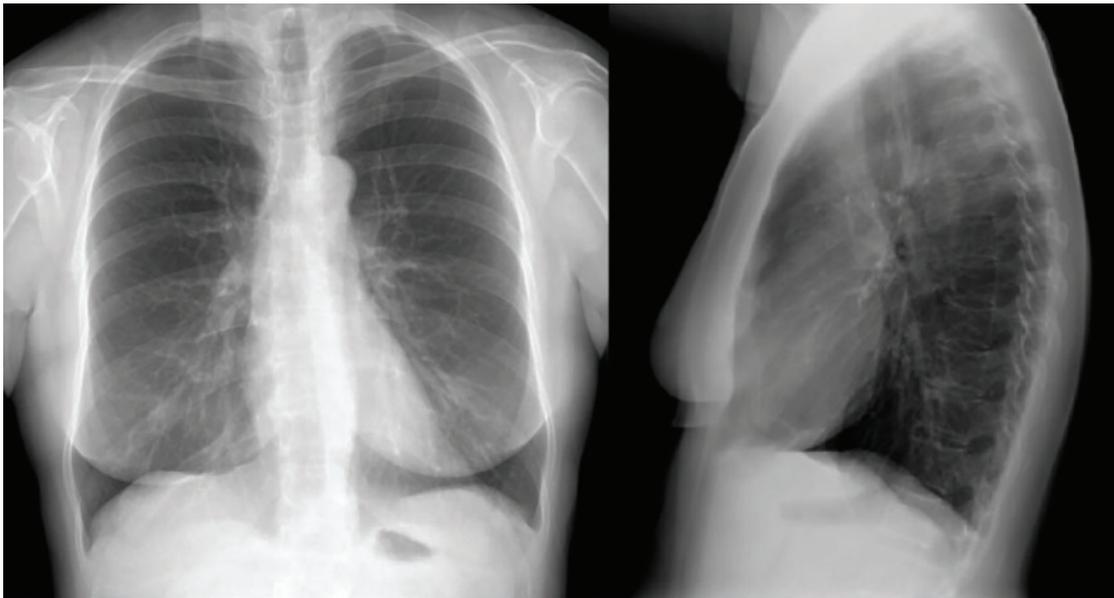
Chest radiography, posteroanterior and lateral views, showed normal findings.
